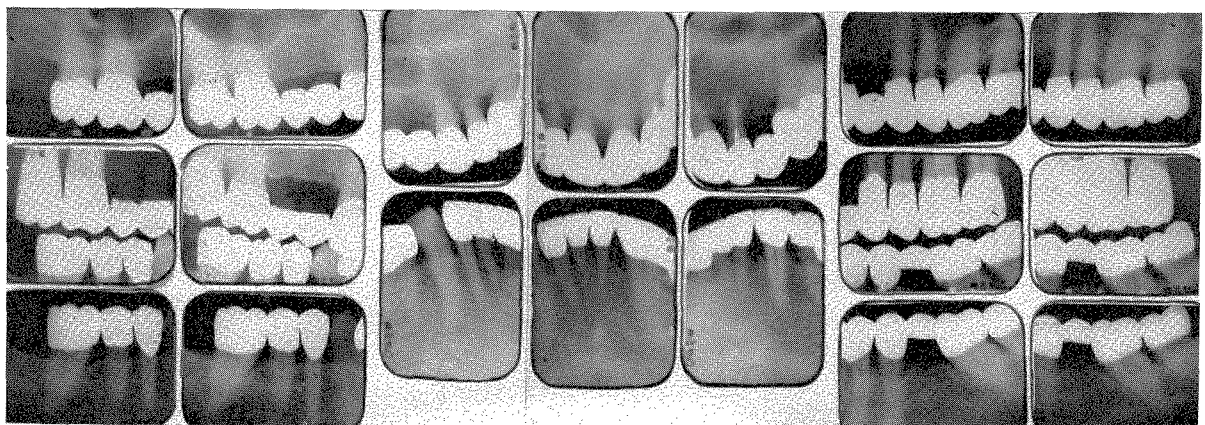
Roentgenograms which were taken in 1962, when the patient was 62 years old.
